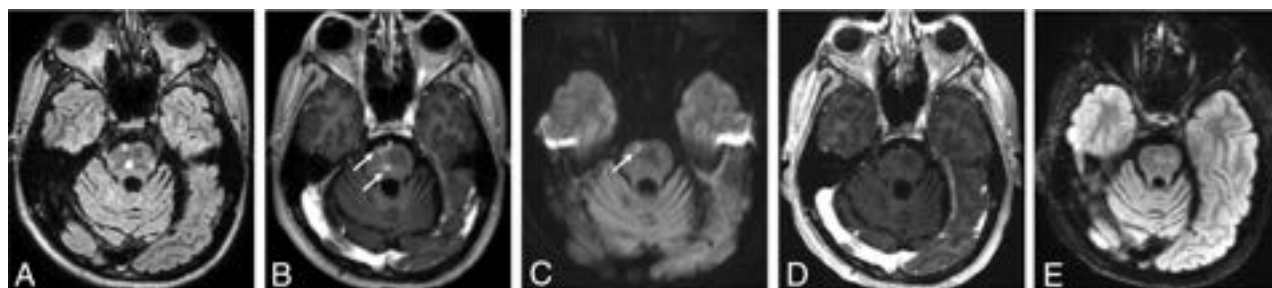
A 60-year-old man with brainstem SMART syndrome. He had a history of posterior fossa medulloblastoma treated with resection and 30 Gy of radiation therapy 16 years ago and presented with emotional lability and slurred speech. He completely recovered from the symptoms. A FLAIR image (A) shows hyperintensity in the central pons with peripheral patchy enhancement on the axial postcontrast T1-weighted image (arrows, B). C, DWI shows focal restricted diffusion in the corresponding area of the enhancing lesion (arrow). D and E, After 6 months, a post-contrast T1-weighted image shows resolution of enhancement with residual slight FLAIR hyperintensity.
